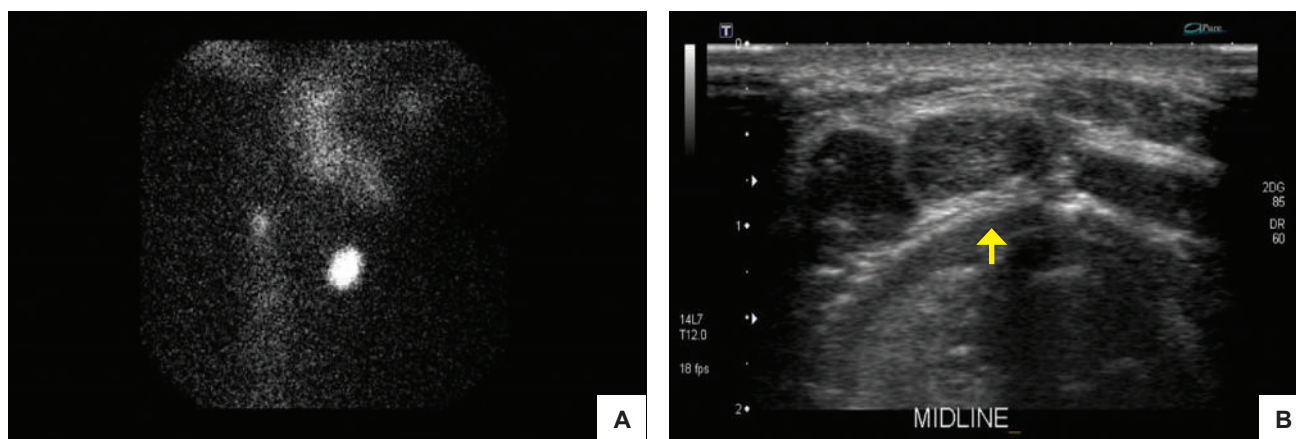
Tc-99 scintigraphy (A) and thyroid ultrasound (B) in 2017 showed a focus of intense radiotracer uptake at the anterior midline neck corresponding to a solid hypoechoic lesion (arrow) superficial to the thyroid cartilage.
